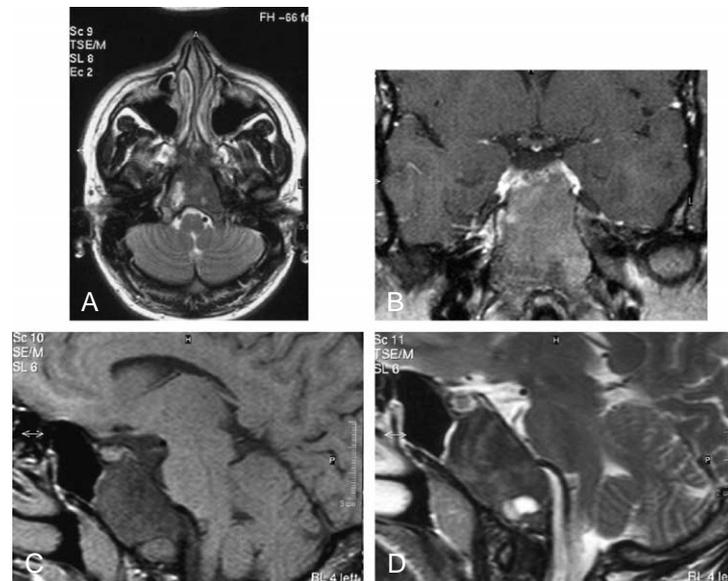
Cranial axial MRI scan showing a hypointense clival lesion on T2-weighted image (A) and mild enhancement on T1-weighted image with Gadolinium in coronal scan (B). T1 (C) and T2 (D) sagittal scans show the hypointense clival lesion with its cystic component.
